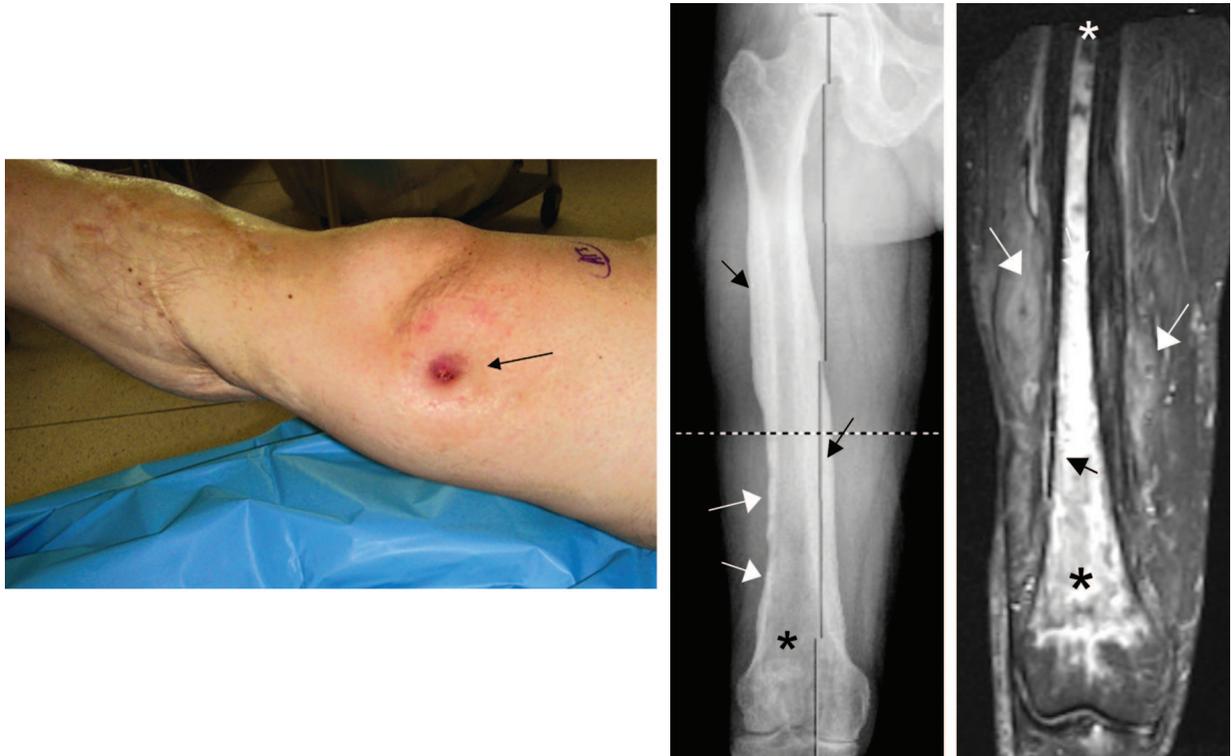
(Left) A draining sinus in the distomedial thigh of a patient with an infected fracture union (femur) seen 30 years after an open fracture initially treated with medullary and then plate fixation. (Center) Anteroposterior radiograph showing reactive callus (black arrows), sequestered lateral cortex (white arrows), and distal osteopenia (*). (Right) A coronal T2, magnetic resonance imaging cut showing the medullary extent of the lesion (*), the sequestered lateral cortex (black arrow), and several abscesses in the soft tissues (white arrows).
